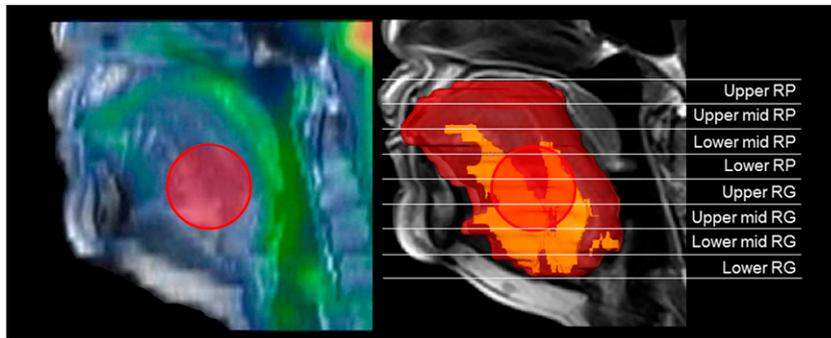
Midsagittal fused positron emission tomography–magnetic resonance images (*left*) and magnetic resonance (*right*) image with volumetric reconstruction of the tongue (*red*) and fat contained within the tongue (*yellow*). The region of interest (*red circle*) from which we measured the standardized uptake value of genioglossus (*left*) is shown in both images and mainly occupies lower retropalatal (RP), upper retroglossal (RG), and upper mid RG regions of tongue. Note that there is significantly more fat at base of tongue (upper RG and upper mid RG) as seen on these positron emission tomography–magnetic resonance images than in upper region of tongue (lower RP).
